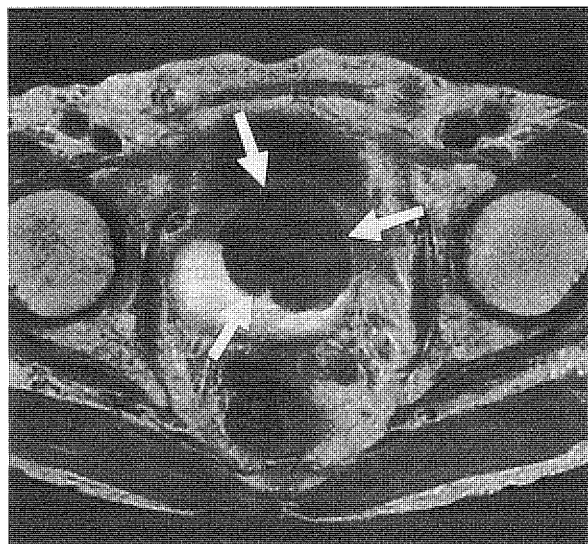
Case 1. MR imaging (T2 weighted image) showed bulky bladder cancer (arrows).
